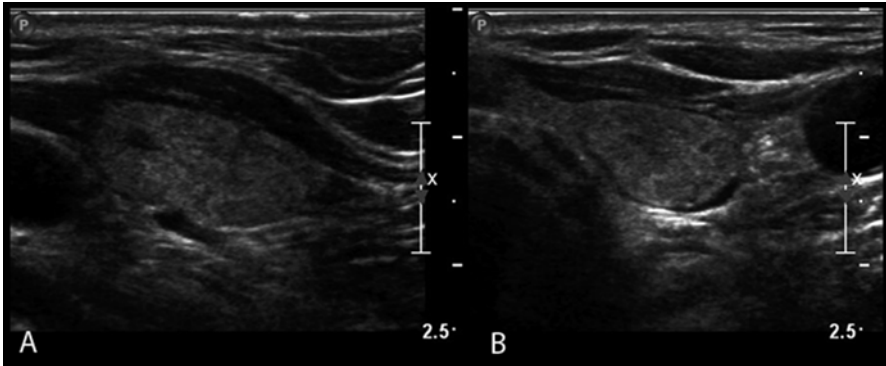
Longitudinal (a) and transverse (b) grayscale sonographic appearance of a $9 \times 13 \times 18$ mm solid, isoechoic, noncalcified nodule with regular margins
